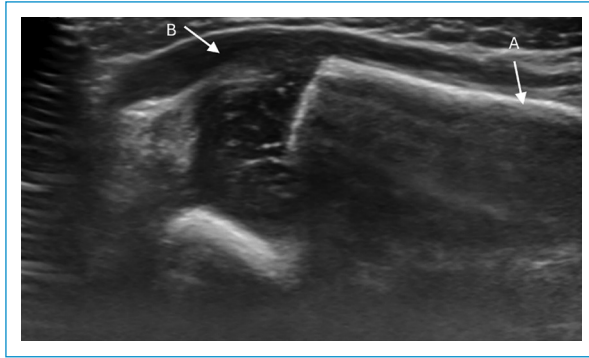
Soft-tissue ultrasound with signs of acute osteomyelitis of the right humerus (A) and no signs of joint effusion (B).
